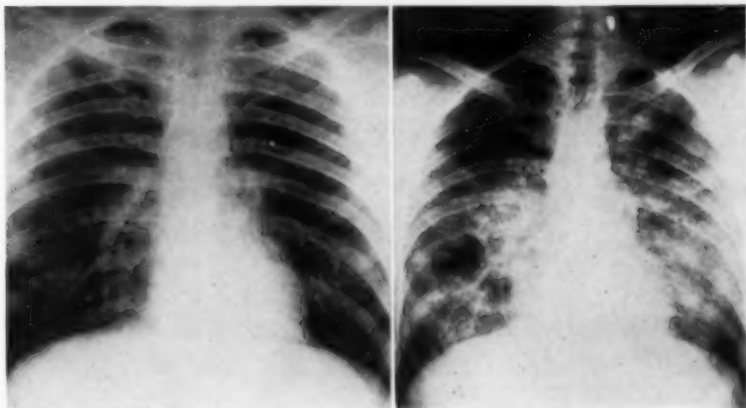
Normal chest x-ray on left, taken 1950. Film on right taken on admission to hospital 1956.
